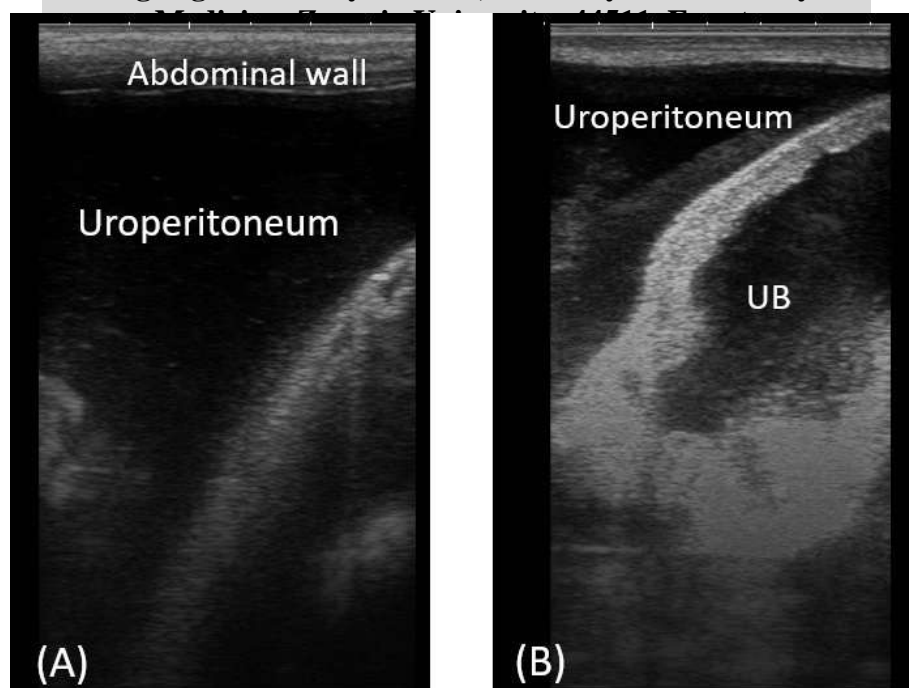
(A) Transabdominal ultrasonographic image of a male buffalo calf with ruptured bladder when examined at the caudal abdomen, uroperitoneum appeared as free anechoic fluid inside the abdomen. (B) Transrectal ultrasonographic image of the same buffalo calf, uroperitoneum with thickened wall, corrugated and shrinkage urinary bladder were noted. UB: Urinary bladder.
